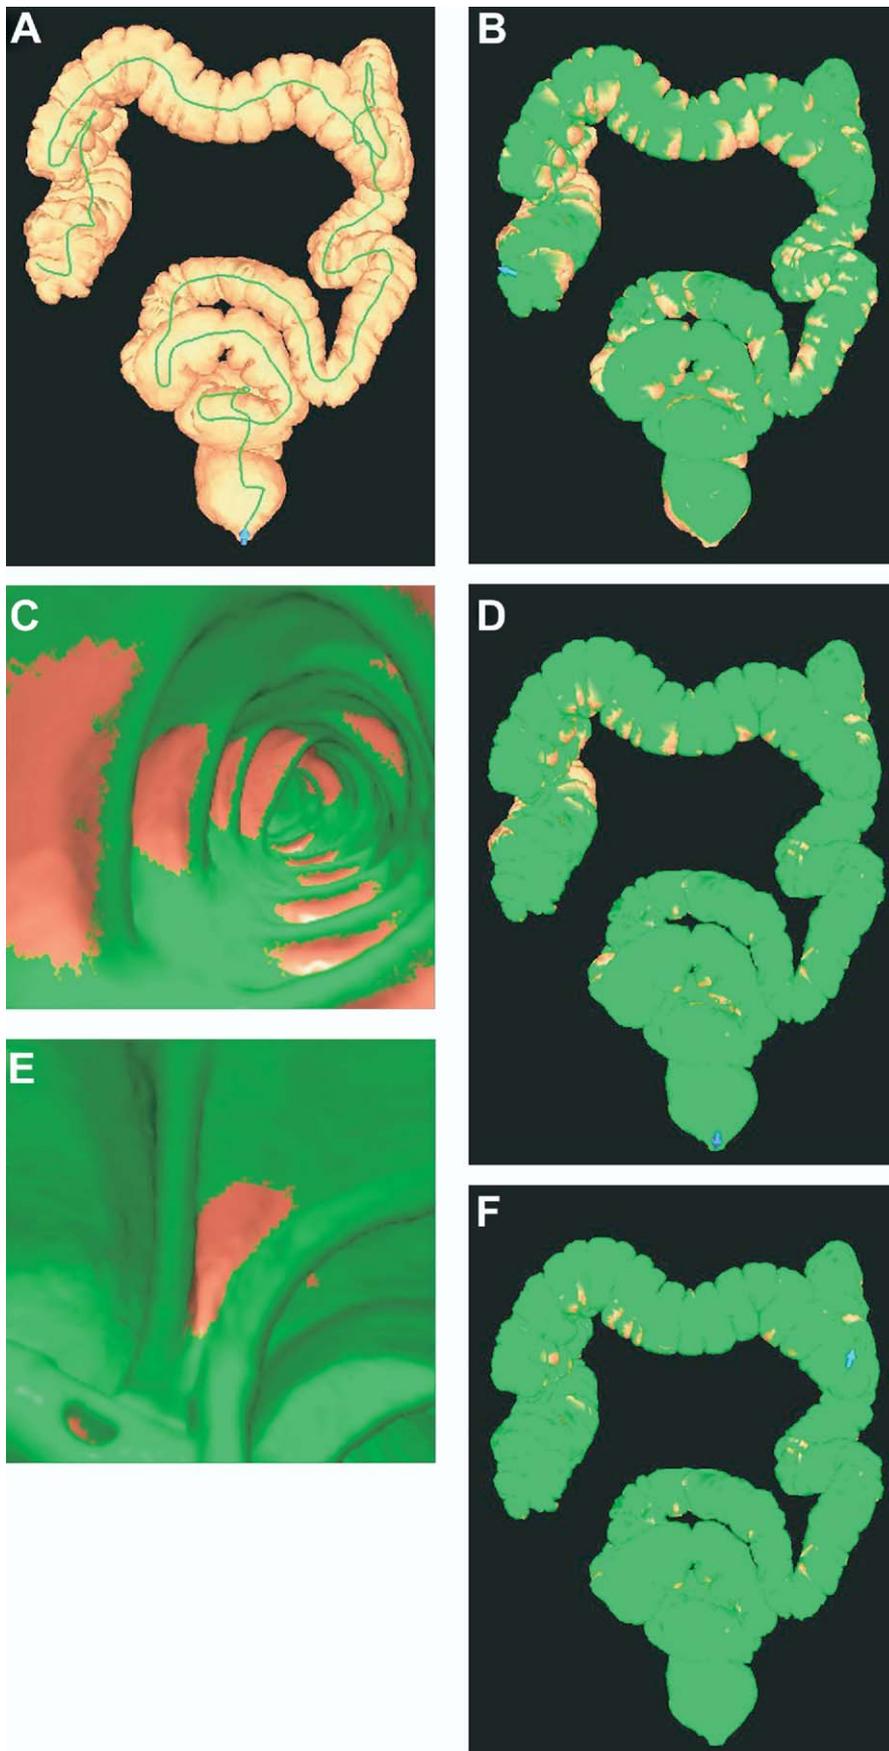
Screening CTC in an asymptomatic average-risk 50-year-old man. (A) Supine 3D colon map extracted from the CT dataset by an automated segmentation step performed by the CTC software system before review. This map is useful for assessing the quality of colonic distention, depicting real-time position during endoluminal navigation, and for showing the location of positive findings. The green line represents the automated centerline for endoluminal fly-through. (B) 3D colon map after retrograde navigation from rectum to cecum depicts the regions of visualized endoluminal surface (painted green). The degree of coverage at this point of the examination was 71% of the total endoluminal surface. (C) The 3D endoluminal view facing in the antegrade direction (toward the rectum) shows the regions of mucosal surface not visualized after unidirectional fly-through in the opposite direction. These areas behind colonic folds represent relative blind spots at OC and are the reason for performing bidirectional evaluation at CTC. (D) The 3D colon map after combined retrograde-antegrade navigation shows the interval increase in the degree of endoluminal coverage (now at 93% in this case). (E) The 3D endoluminal view obtained during use of the missed region tool shows a typical surface patch not seen after routine bidirectional navigation. Most missed patches are located between folds, particularly at the inner turn of flexures. Note that the inner aspect of the adjacent diverticulum also evaded visualization at routine evaluation. (F) The 3D colon map shows the effect of rapid review of all missed patches 300 mm² or larger in surface area that were not seen after the initial bidirectional fly-through, which increased the overall surface coverage to 98%. The use of the missed region tool added 20 seconds to the interpretation of this case.
